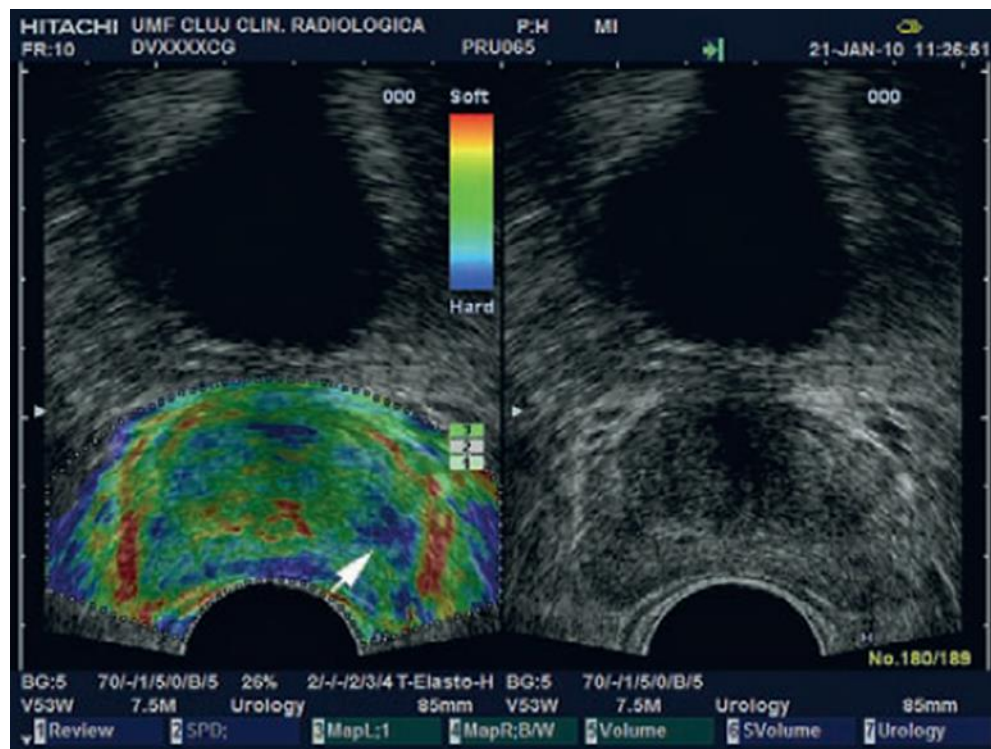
Strain elastography (SE) (left) and ultrasound (right) images of a prostate with a stiff and malignant nodule pointed by arrow. Adapted from Guirgiu et al. 2011 [55].
